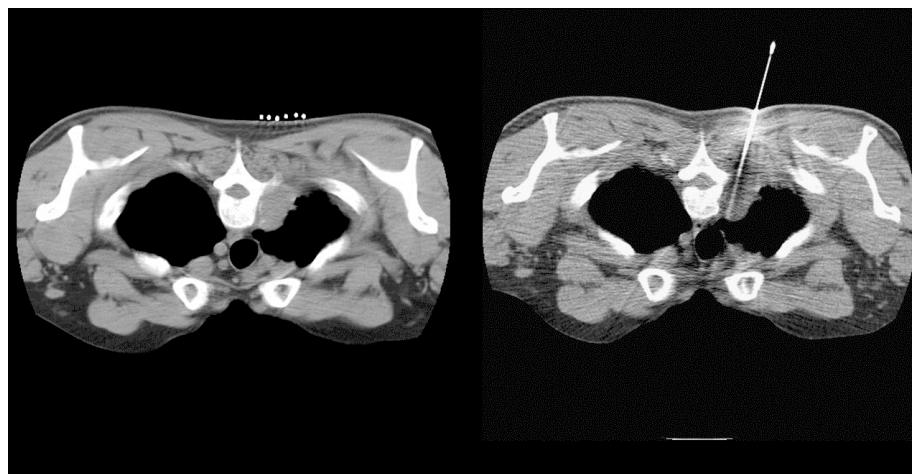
A plan scan for preparing a puncture allows identification of the target (left). During a CT fluoroscopy guided puncture, the position of the needle can be visualized accurately (right).
